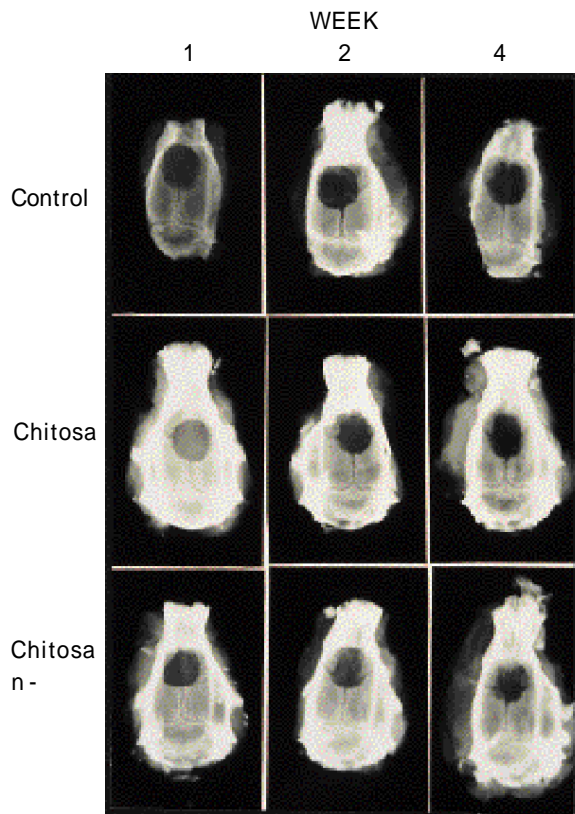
Radiographs of calvarial defects at
